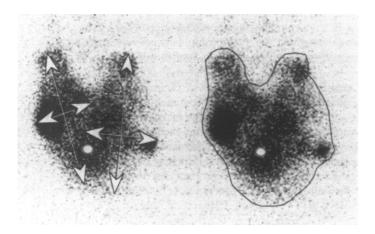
Examples of scintigraphic volume estimation with the cylinder (left) and volume models (right) in patient 9.
